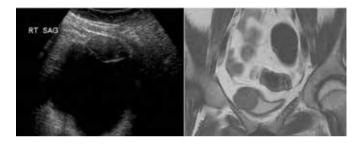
Bladder leiomyoma in an 18-year-old woman. (a) Right sagittal US image showing a hypoechoic lesion of the anterior bladder wall. (b) Coronal T2-weighted MR image shows a round bladder mass that is isointense to the muscle. 4
